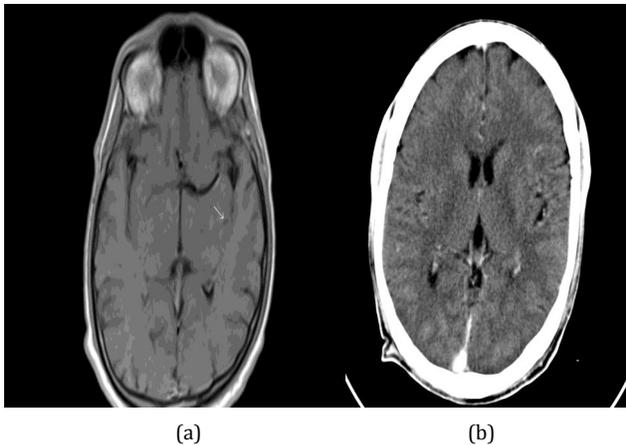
2 a & b– Stage 1 active neurocysticercosis. (a) Axial gadolinium enhanced T1W MRI shows a faintly ring enhancing lesion (white arrow) in the left temporal lobe with no perilesional edema which is not appreciated in the contrast enhanced CT axial scan of the brain at the same level (b).
